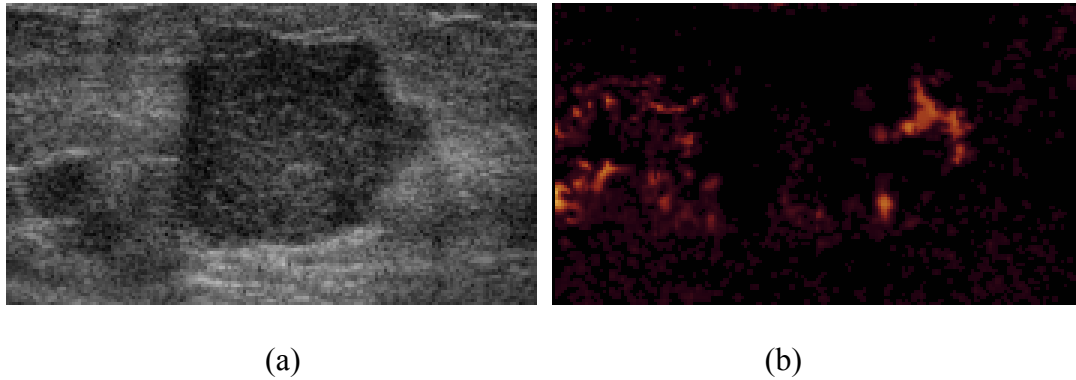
(a) The ultrasound image of a malignant tumor, and (b) its corresponding ultrasound power Doppler imaging.
